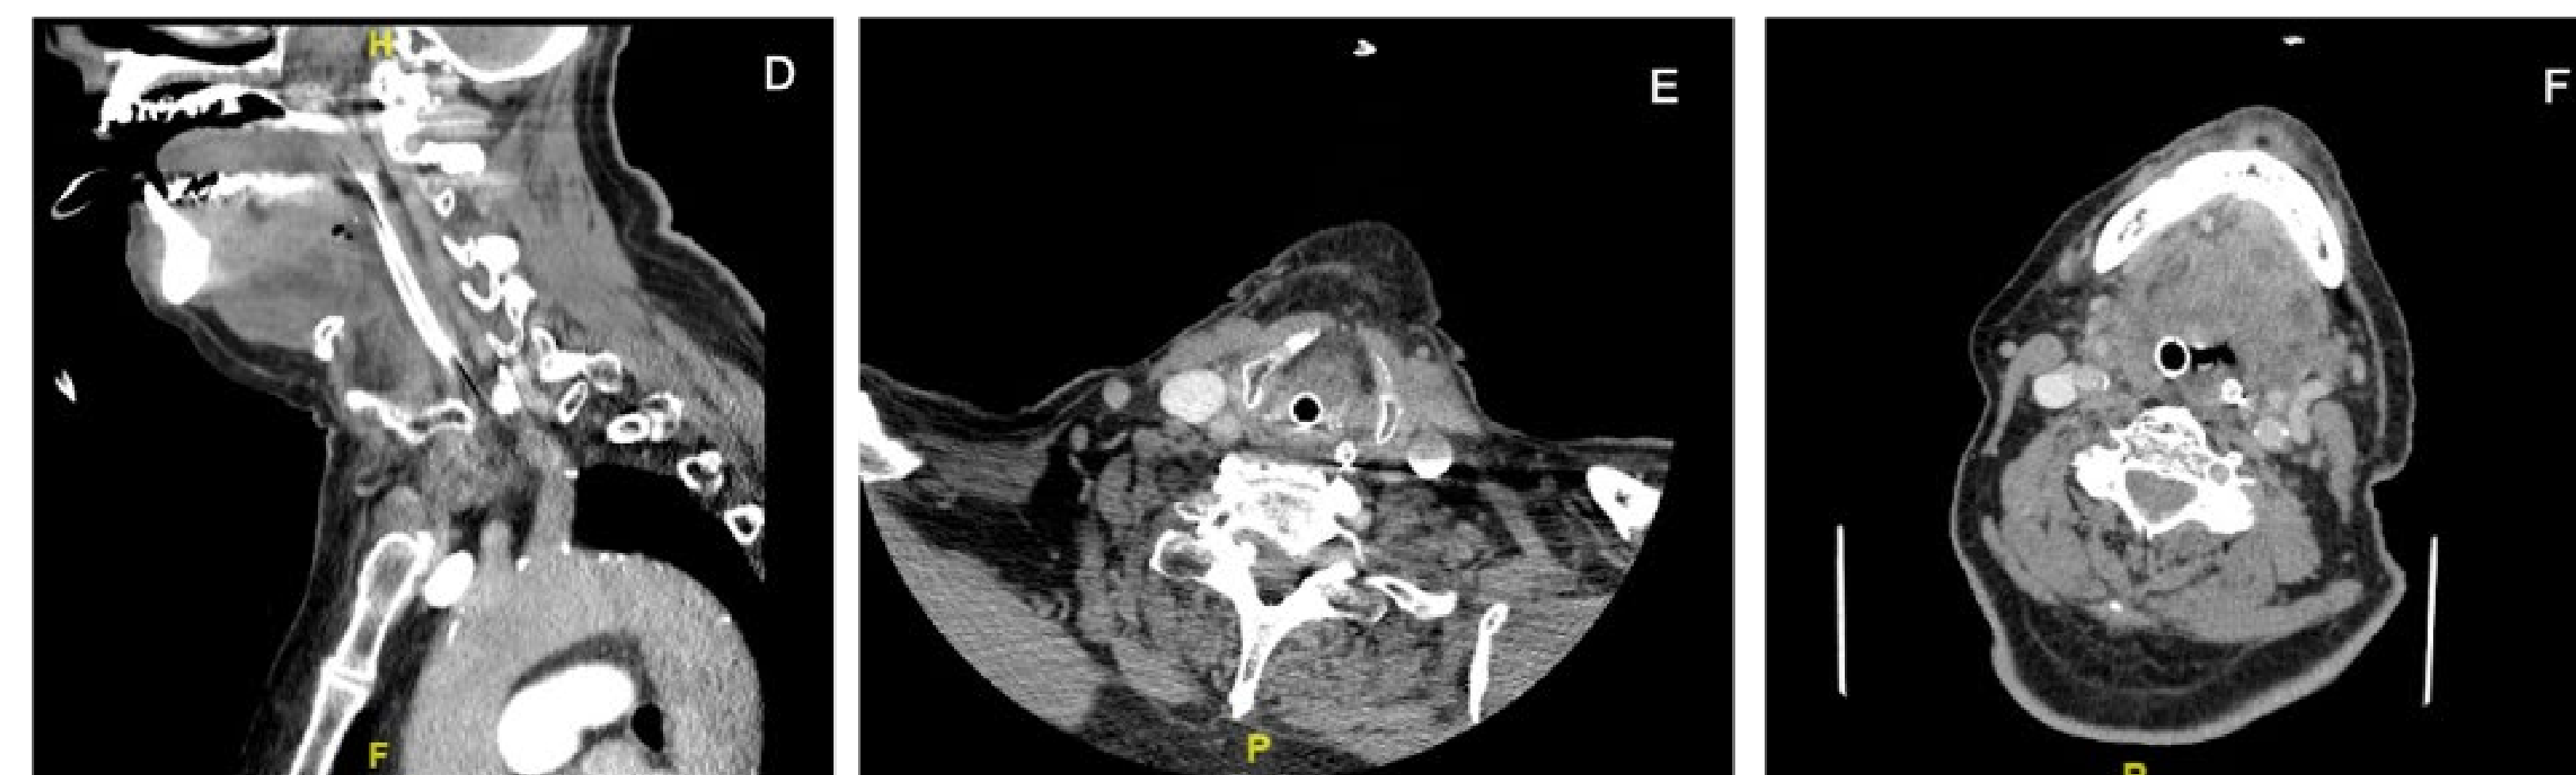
Images from the follow-up CT scan with contrast of the head and neck on day 4 of admission, revealing (D) re-demonstrated subglottic edema and swelling, (E) re-demonstrated subcutaneous fat stranding in anterior neck tissues, and (F) progression of myositis and diffuse edema of the oropharynx and mouth floor musculature.
